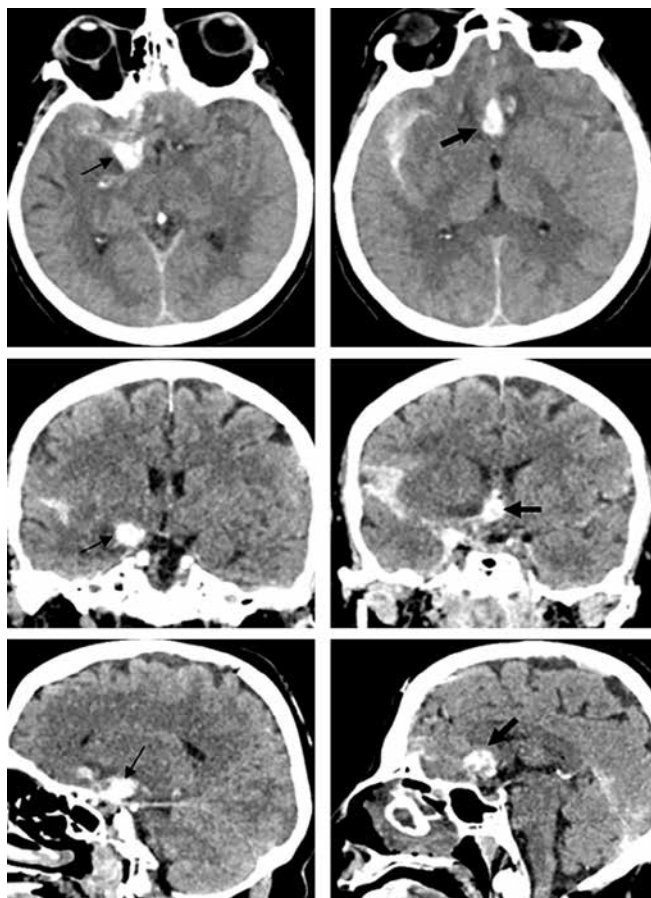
Brain multispiral computed tomography of female patient N. (native). A thin black arrow shows a hemorrhage in the area of the bifurcation of internal carotid artery aneurysm, a thick black arrow shows a hemorrhage in the area of the anterior communicating artery aneurysm
